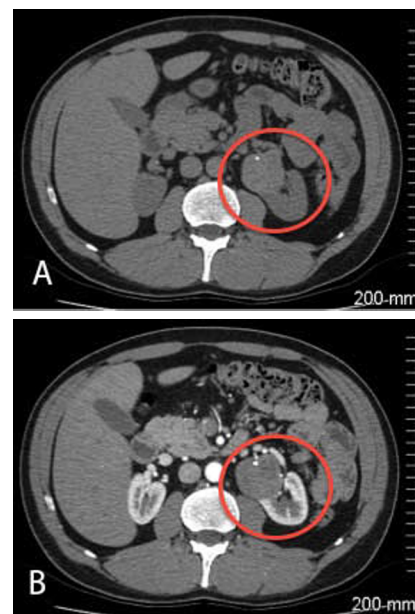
Computed tomography imaging of axial slices, unenhanced (A) and enhanced (B), showing left renal carcinoid (circled in red) in horseshoe kidney.
